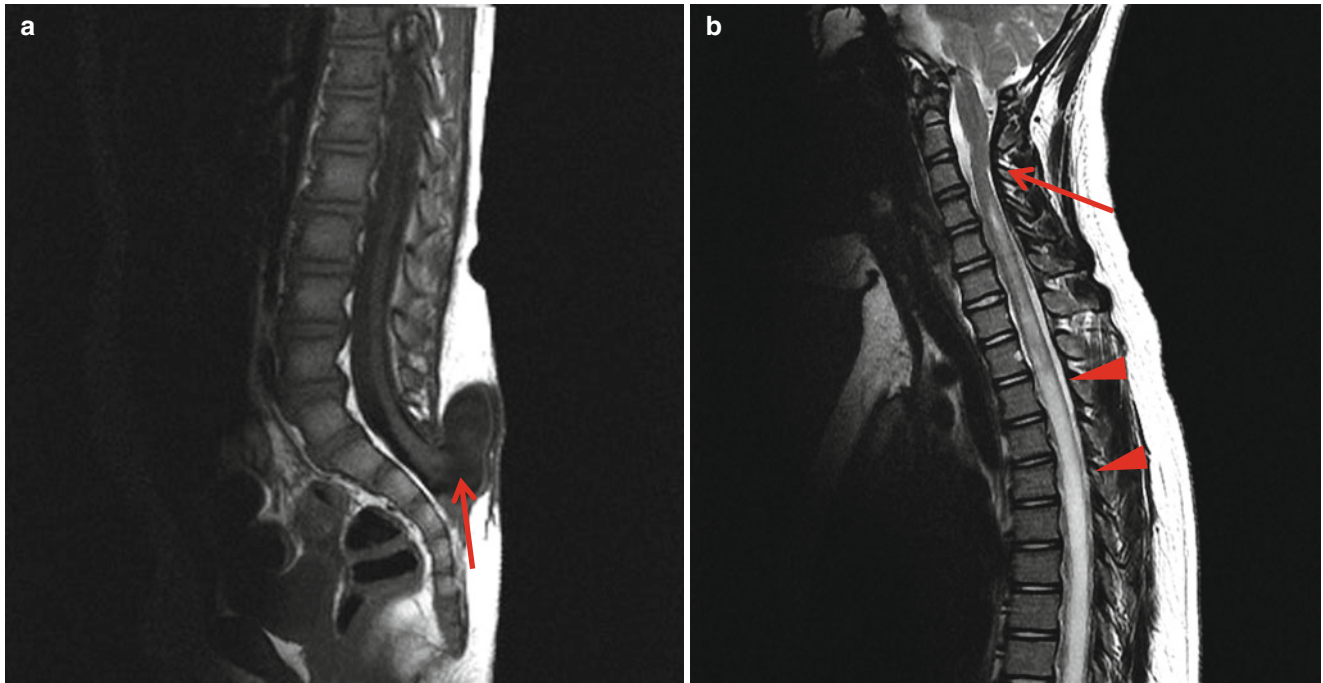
Myelomeningocele. (a) T1-weighted image shows herniation of the distal cord connected with neural placode (*arrow*). (b) T2-weighted image shows Chiari malformation with cervicomedullary kink (*arrow*) and distal syringomyelia (*arrowheads*)
